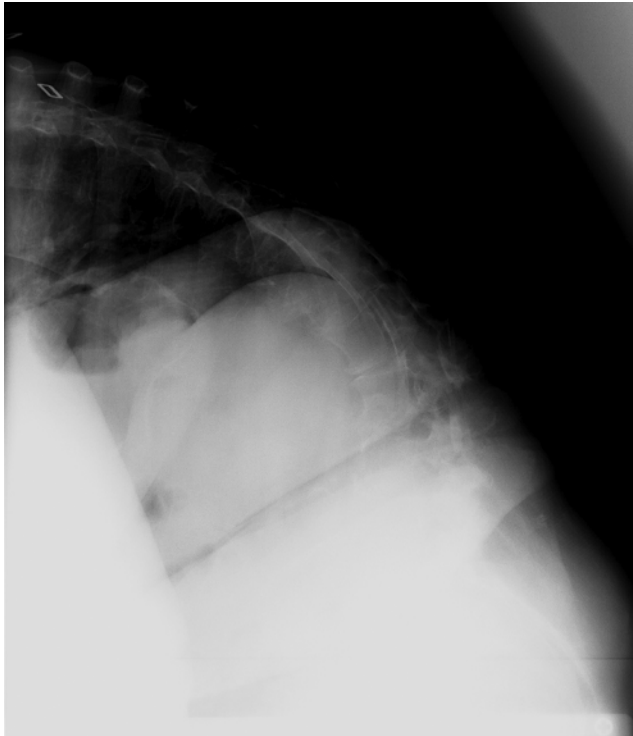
Case 4. Preoperative radiograph showing significant sagittal imbalance.
